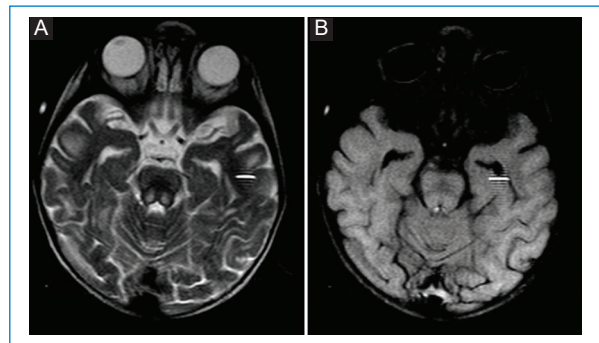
A: T2-weighted imaging axial showing hyperintensity involving the pontine tegmentum of the upper pons in the central tegmental tracts. B: fluid-attenuated inversion recovery axial showing hyperintensity involving the pontine tegmentum of the upper pons in the central tegmental tracts.
